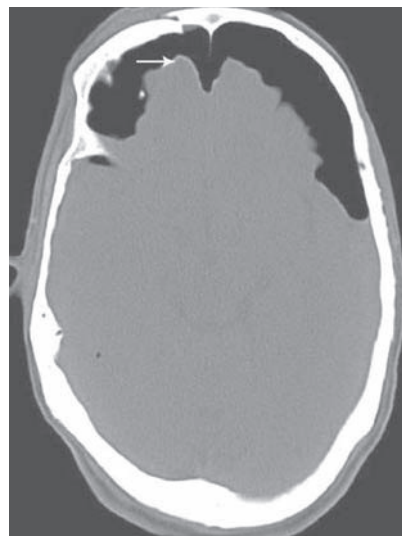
Non-enhanced CT image of brain showing fracture of frontal bone with bilateral frontal subdural hypoattenuation with compressed and widely separated frontal lobar tips (see arrow)
